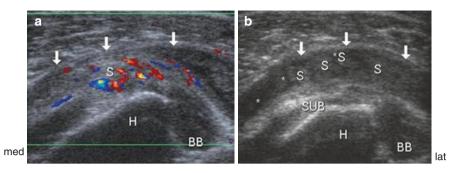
Subacromial-subdeltoid bursitis. (a, b) (Transverse view): humeral head (*H*), tendon of the long head of the biceps brachii (*BB*), subscapularis (*SUB*), anterior recess of bursa (*down arrow*), thickened synovial sheath (*S*) and residual space of bursa filled with fluid (*asterisk*). (a) Hyperaemia in colour Doppler US; modified according to ref. [13]
